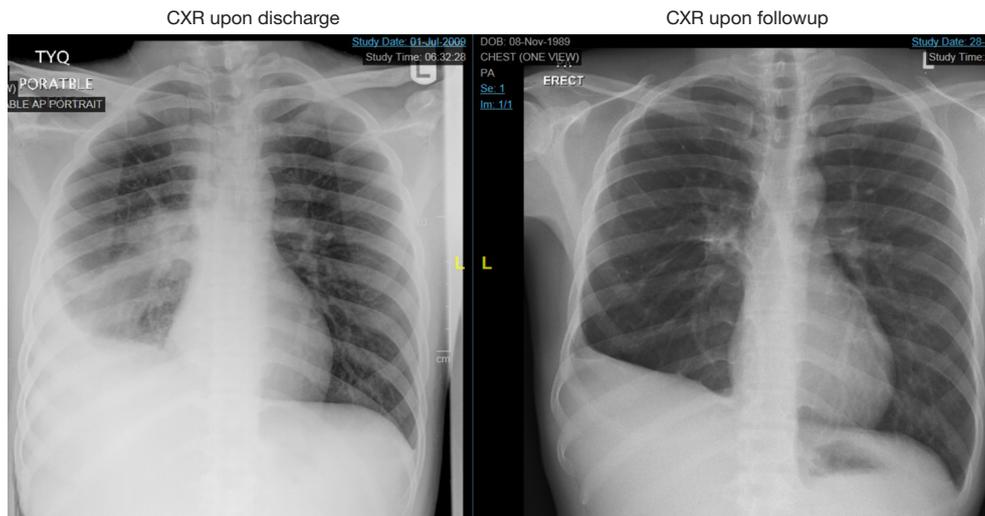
Chest radiograph upon discharge and on follow-up, showing expected volume loss post lobectomy.
